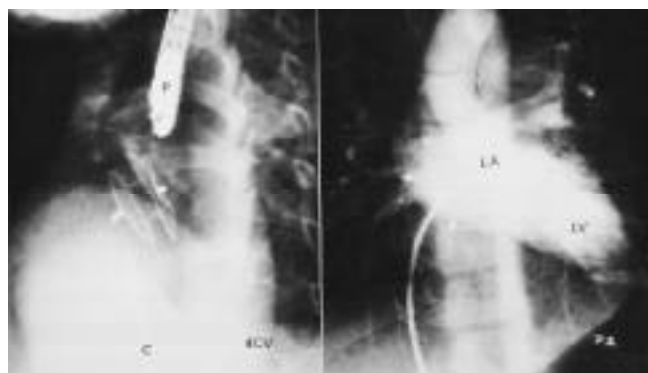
Left frame showing deployment of Amplatzer 17 mm septal occluder with delivery catheter (C) just being withdrawn in four-chamber projection (4CV) under transoesophageal guidance (P = multiplane paediatric TEE probe). Right frame showing normal pulmonary venous return into left atrium (LA) and subsequently left ventricle (LV) in postero-anterior (PA) projection without detectable residual left to right shunt across Amplatzer septal occluder (marked by 2 white arrows).
